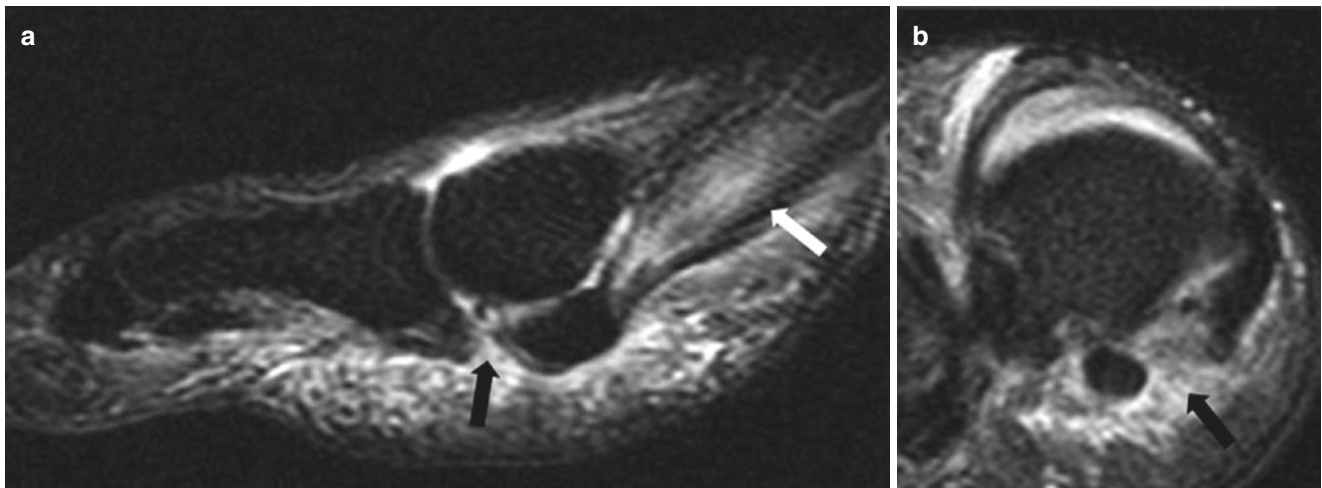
Plantar plate tear (great toe). Sagittal (a) and coronal (b) fat-suppressed T2-weighted MR images of the right forefoot demonstrate tearing of the medial sesamoid phalangeal ligament (*black arrows*) and strain of the abductor hallucis muscle (*white arrow*)
